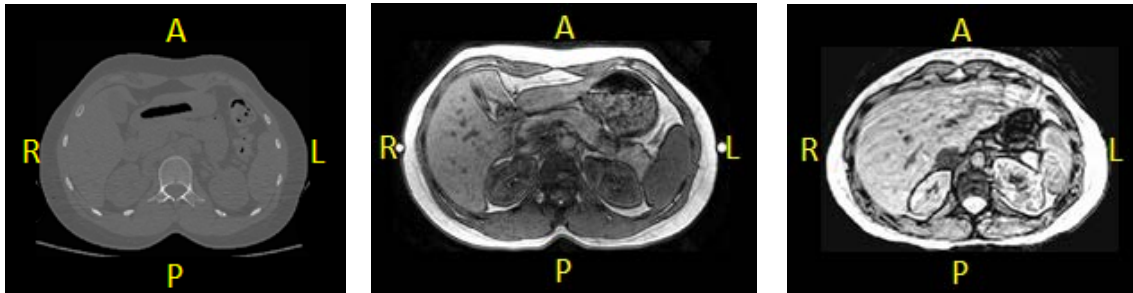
Examples of the Multi-Modality Image Set, a) Axial slice of supine CT, b) Axial slice of supine MRI, c) Axial slice of seated uMRI. Each image was taken at the level of the 3rd lumbar vertebra.
